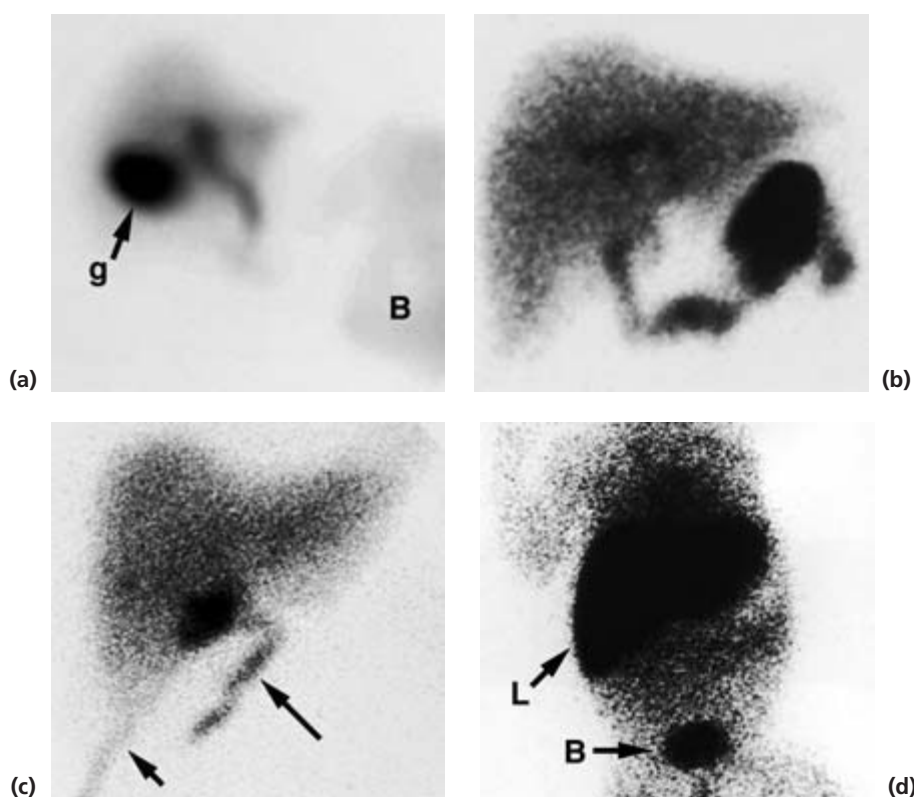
Cholescintigraphy (^{99m}Tc Iodida). (a) Normal scan. At 30 min the gallbladder (g) has filled. Isotope has already entered the bowel (B). (b) Acute cholecystitis. Gallbladder has not filled by 60 min (c) Post-cholecystectomy bile leak. Isotope tracks laterally from gallbladder bed (short arrow) and T-tube track (long arrow). (d) Two-week-old infant with severe jaundice. Radio-activity is concentrated in the liver (L) and did not enter the bowel. Biliary atresia was confirmed. B, bladder.
